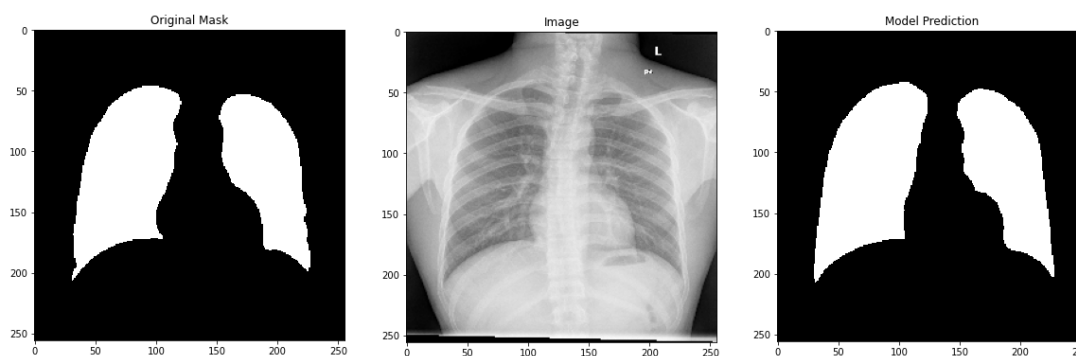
Example of U-Net image segmentation trained on a lung X-Ray dataset. The left image is the original mask created by an expert using the center image. The right image is the output of a trained U-Net model that has never seen the center image before.
